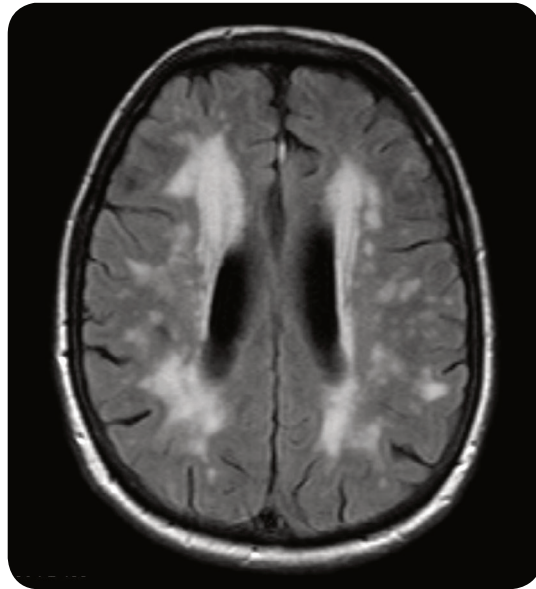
An MRI scan in the axial plane of the head of an individual with cognitive impairment. There are multiple small white matter infarcts and an absence of cortical atrophy.
